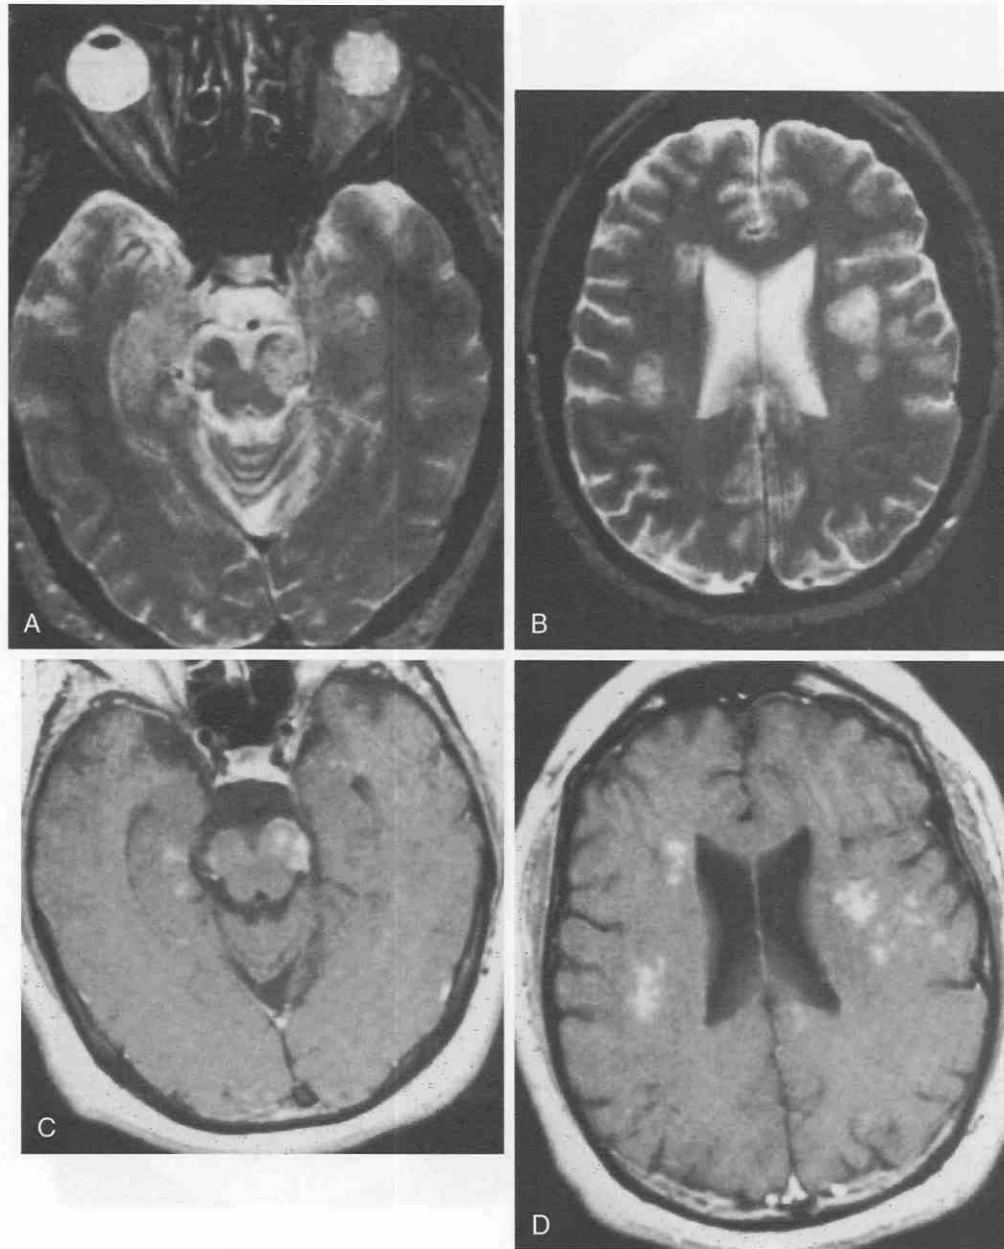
Acute disseminated encephalomyelopathy (ADEM) in a 52-year-old man with memory loss, apathy, and inflammatory cells in the cerebrospinal fluid. *A* and *B*, Cranial MR T2-weighted axial images show multiple, hyperintense lesions involving the right medial temporal lobe, both cerebral peduncles, and the mesencephalic deep white matter. *C* and *D*, Gadolinium contrast-enhanced, T1-weighted MR images at the same levels show patchy multinodular contrast enhancement within the lesions.
